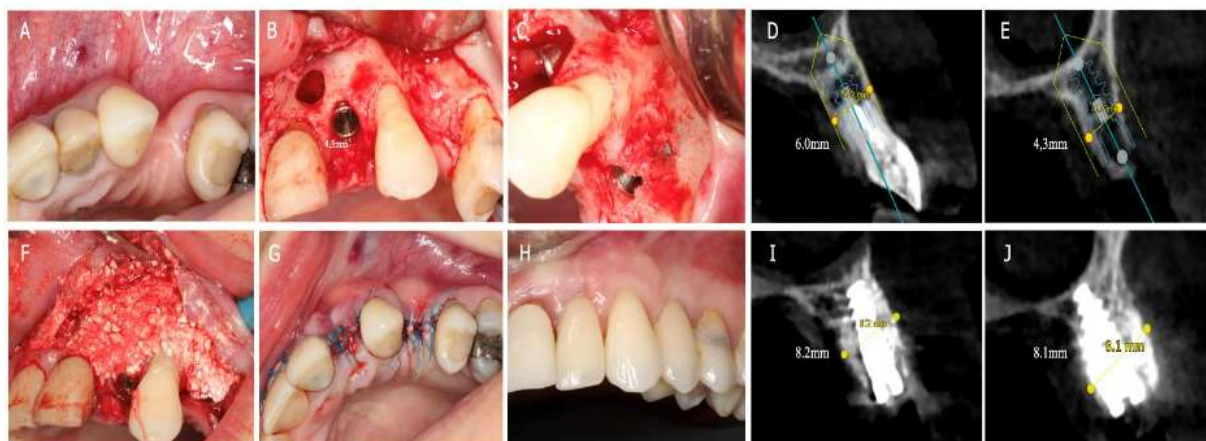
Horizontal augmentation with immediate implant placement. A- initial presentation, B- flap elevation and lateral incisor implant placement, C- 1<sup>st</sup> premolar implant with buccal bone fenestration, D- initial CBCT cross-section of the lateral incisor, E- initial CBCT cross-section of the 1<sup>st</sup> premolar, F- BA bone graft placed, G- flap sutured in tension with maximum closure (1mm of BA exposed), H- 5-year follow-up post restoration, I- 6-month post op CBCT cross-section of the lateral incisor, and J- 6-month post op CBCT cross-section of the 1<sup>st</sup> premolar.
